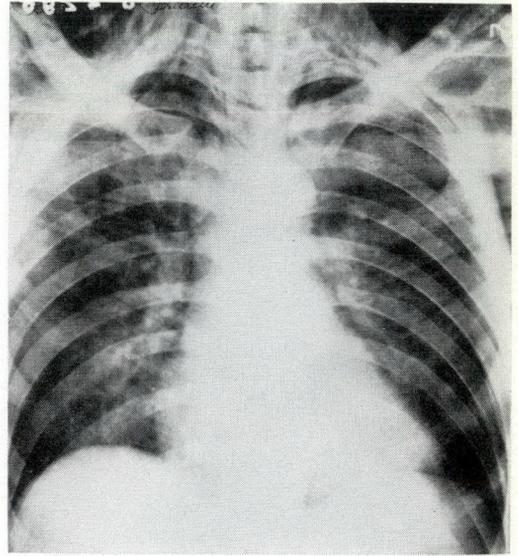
Admission radiograph of tear of Type 1 (trachea), showing marked subcutaneous emphysema and no pneumothorax.
